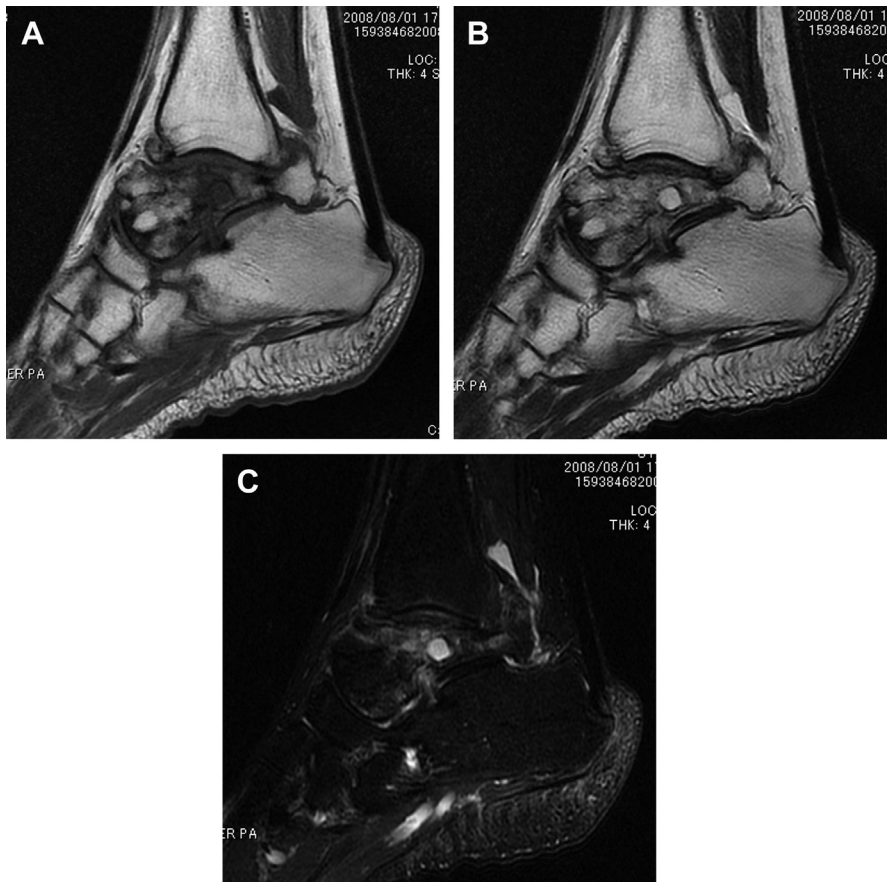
MRI of a 52-year-old woman. (A) In the T1-weighted image, a low-density area is seen in the body of the talus. (B) In the T2-weighted image, a high-density area is seen in the body of the talus, and bony cyst is identified in it. (C) In fat-suppressed T2-weighted image, a mixture of high-intensity and low-intensity areas is seen, reflecting bone marrow edema and necrosis, respectively.
